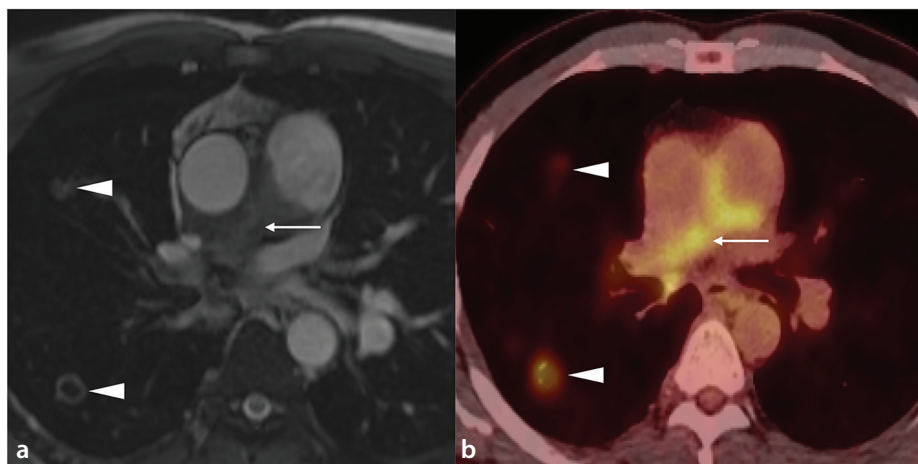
Large vessel vasculitis with pulmonary arterial involvement. (a) Axial magnetic resonance image with soft tissue thickening involving the right pulmonary artery (thin arrow) and small cavitating and non-cavitating lesions in the right lung (arrowheads); (b) corresponding axial positron emission tomography/computed tomography shows both pulmonary vascular and lung parenchymal lesions to be fluorodeoxyglucose avid.
